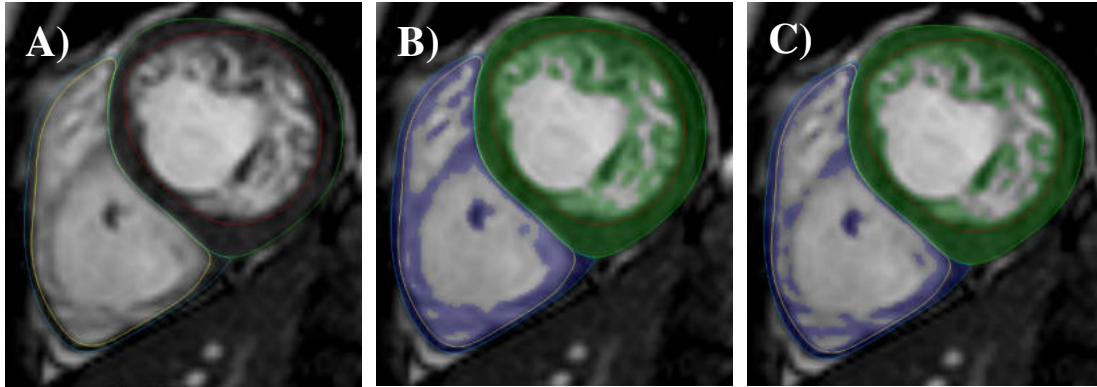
The conventional countouring (image A) and threshold-based post-processing methods with 70% (image B) and 50% (image C) thresholds on short-axis CMR images of left ventricular noncompaction (63). According to the conventinal countouging technique (image A), myocardial mass is defined as the area between the endocardial contour (red for LV and yellow for RV) and epicardial contour (green for LV and blue for RV), while the area within the endocardial border is considered as blood volume. In contrast, the threshold-based method (images B and C) visualizes the intracavitar trabecular meshwork by highlighting it in green (LV) and purple (RV). Consequently, the area between the endocardial and epicardial borders corresponds to the compact myocardium. LV = left ventricle, RV = right ventricle, CMR = cardiac magnetic resonance imaging.*
